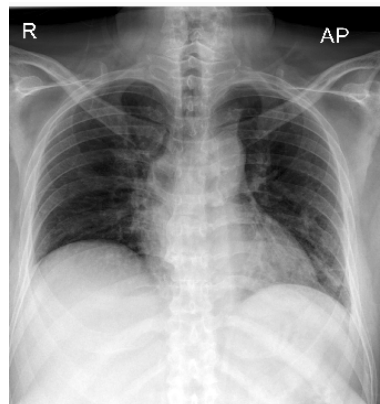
Normal chest X-ray after treatment with rituximab on 19 August 2025.
